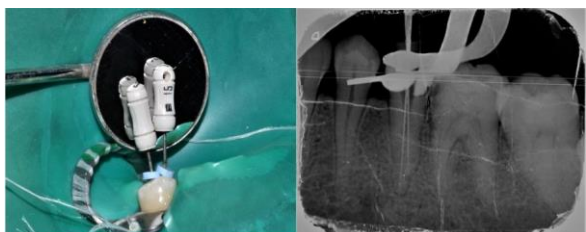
Working length radiograph of with tooth #35.
